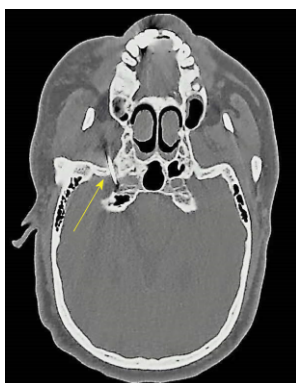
Computed tomographic image showing the introducer needle and coblation wand (yellow arrow). The coblation wand extended approximately 5 mm beyond the introducer needle.
